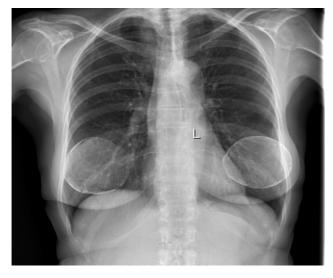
Radiography showing implant calcification. A radiological image reveals mineralization of both breast implants.
